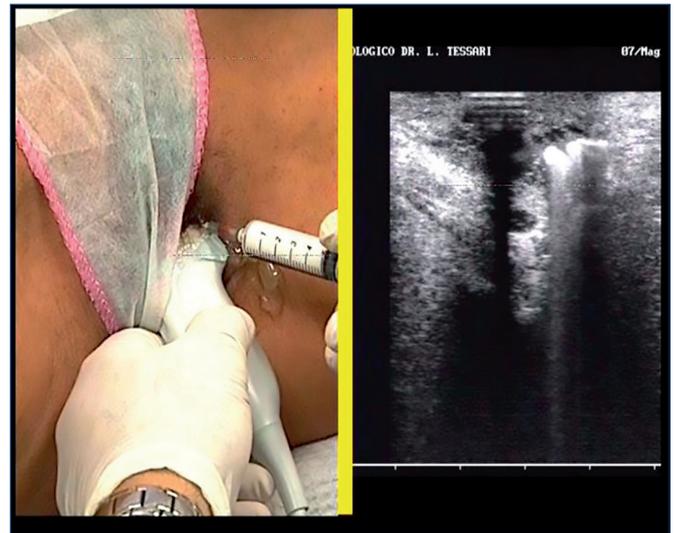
Direct foam sclerotherapy injection and sonographic visualization of the treated venous plexus.
